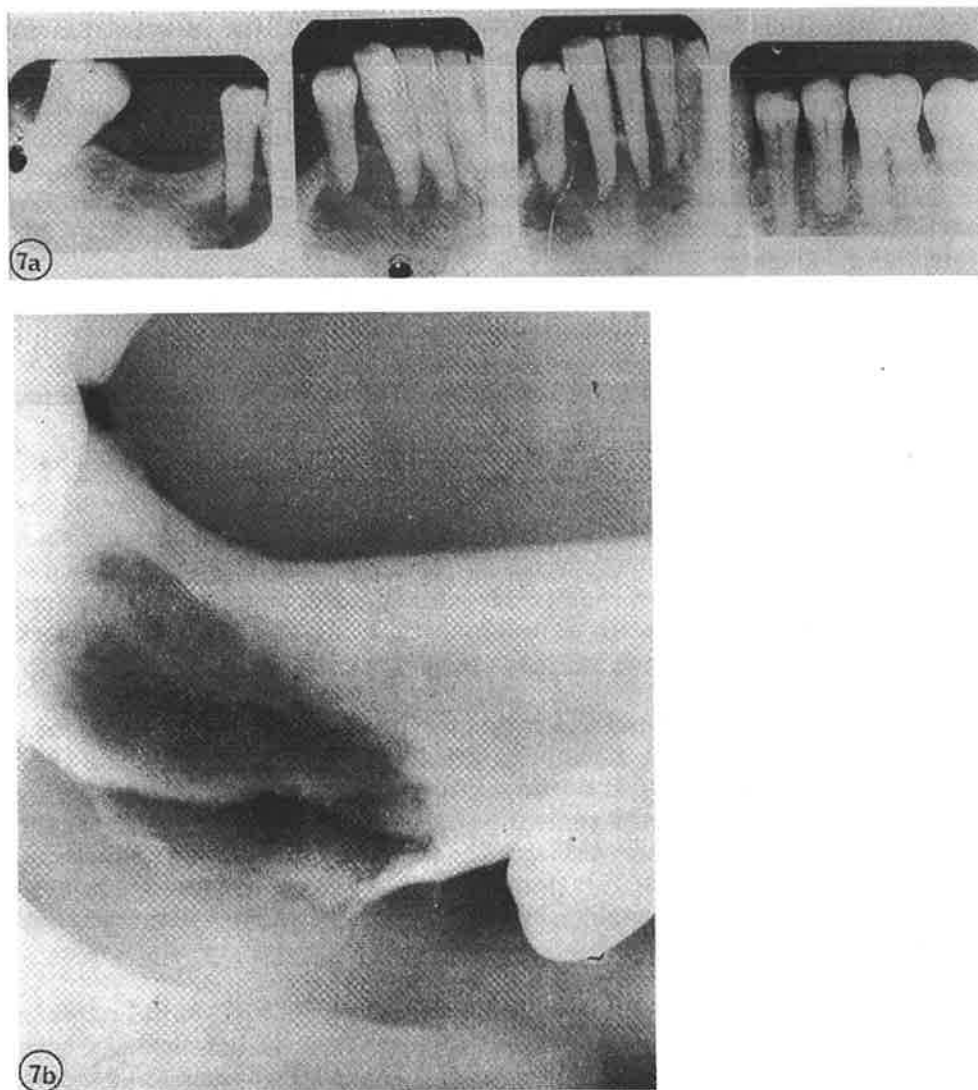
Case 2. a. *Periapical radiographs of loose anterior teeth at presentation to general dental practitioner. b.* *4 weeks after removal of loose anterior teeth.*
